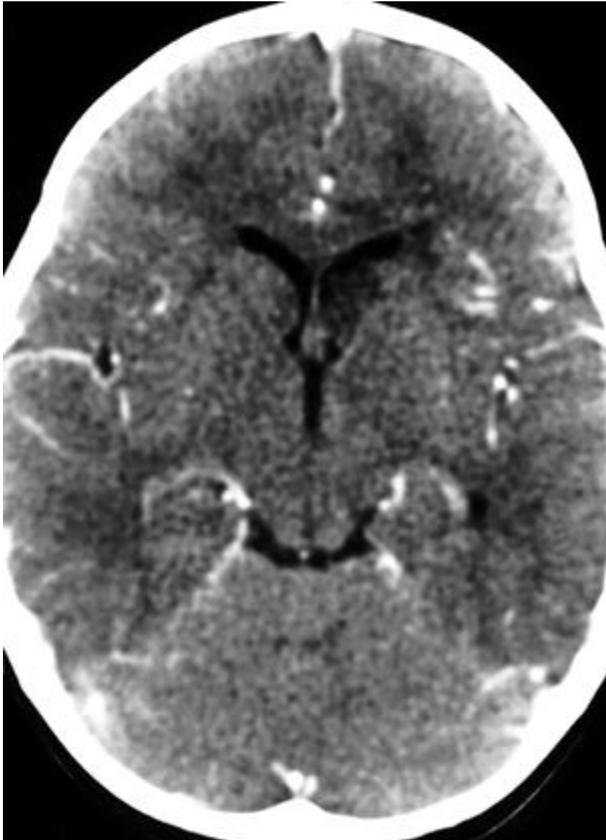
Post-contrast axial CT scan reveals well-defined low density lesion on both head of caudate nuclei and left lentiform nucleus. In the left frontal lobe, periventricular white matter area, a subtle low-density lesion is shown.
